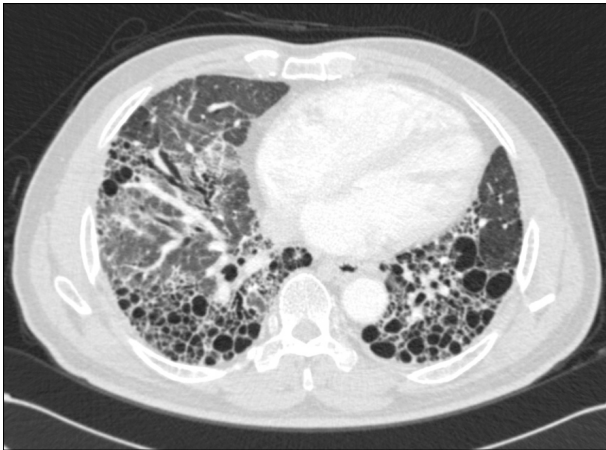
Preoperative chest computed tomography. Subpleural and peribronchovascular reticulation with macrocystic honeycombing is visible in both lungs.
